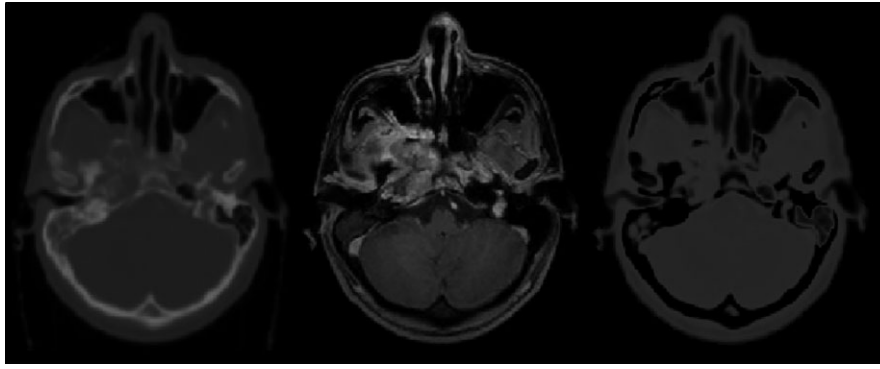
Example of bone suppression/replacement technique to improve the similarity between CT and MRI: (left) original CT image, (middle), in-phase MR image and (right), bone-suppressed CT. All images are co-registered and from patient #1.
